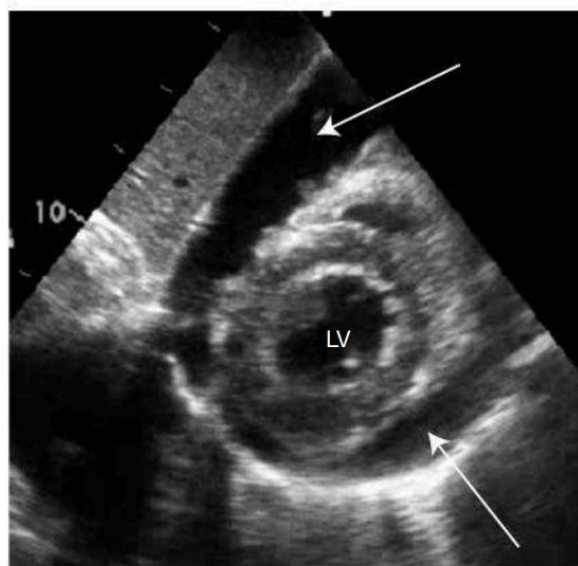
Pericardial effusion: echocardiogram (apical view). Short-axis view of the heart showing a large circumferential pericardial effusion (arrows). (LV = left ventricle)
